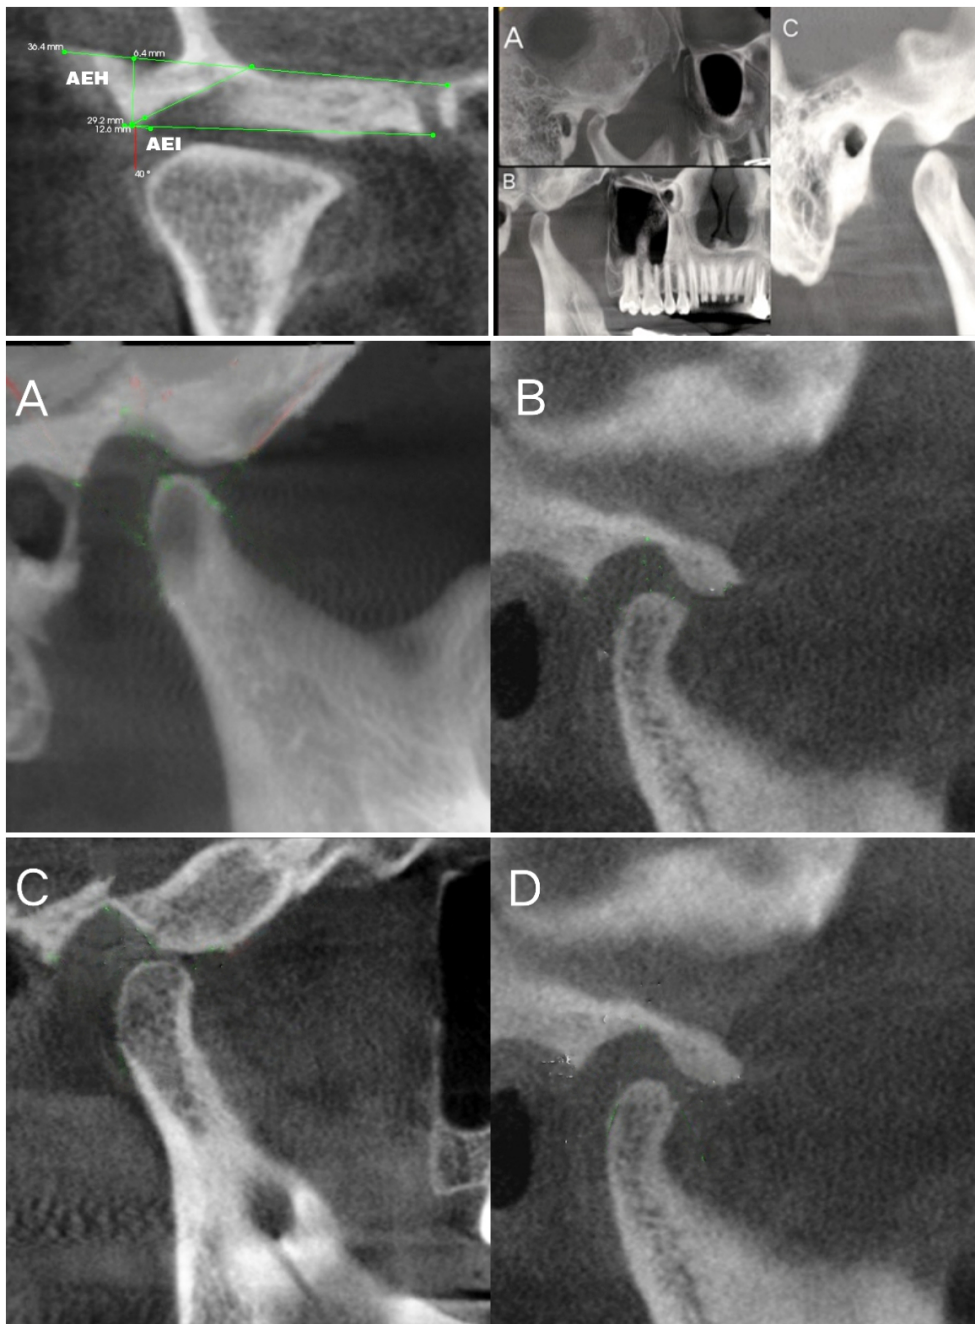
Assessment of articular eminence height and inclination in the sagittal view of CBCT, as well as view of condylar changes in the coronal plane, classified as 1. (A). Osteophyte (B). Erosion (C). Normal and different glenoid fossa shapes, which are further classified as (A). Triangular; (B). flattened; (C). oval; (D). round.
